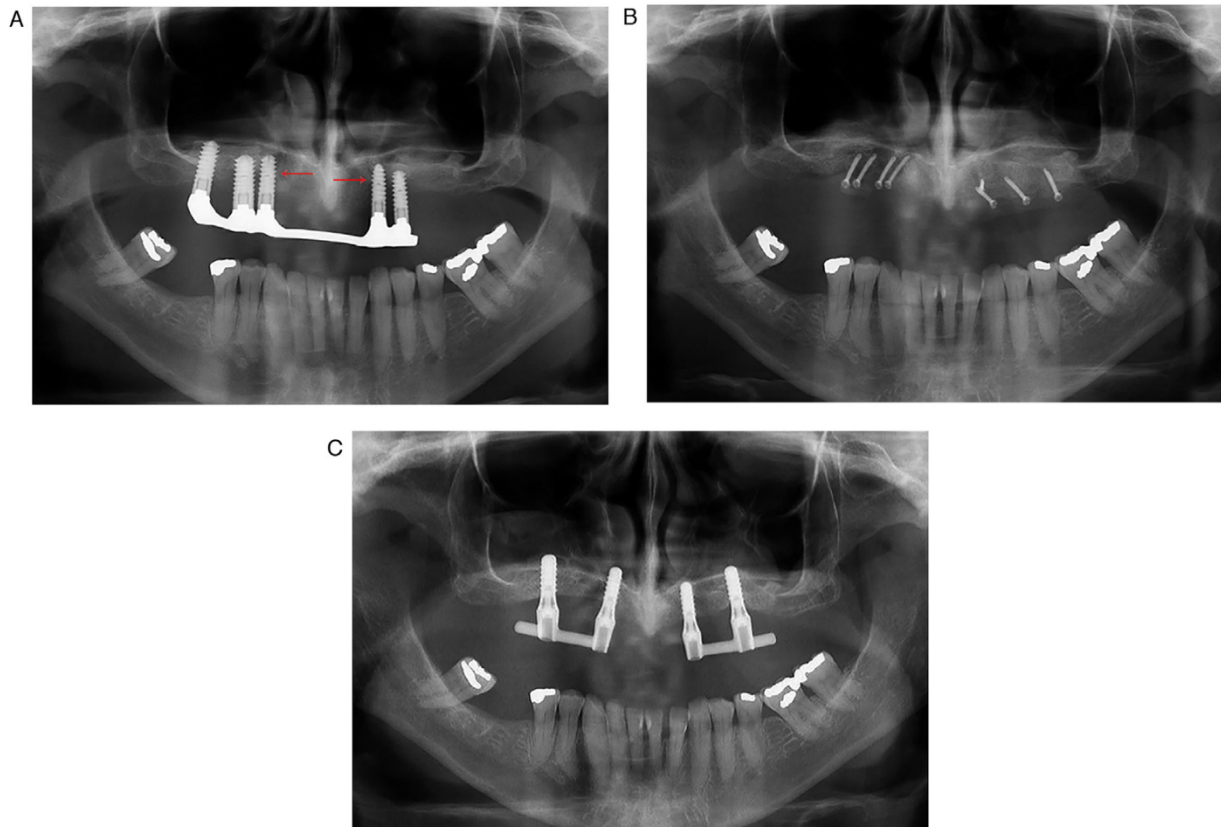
Panoramic radiographs of one of the patients. (A) Baseline panoramic radiograph showing evident marginal bone loss around the failed maxillary implants (red arrows). (B) Panoramic radiograph after implant removal and bone augmentation. (C) Panoramic radiograph at the time of evaluation (13 months in function).
